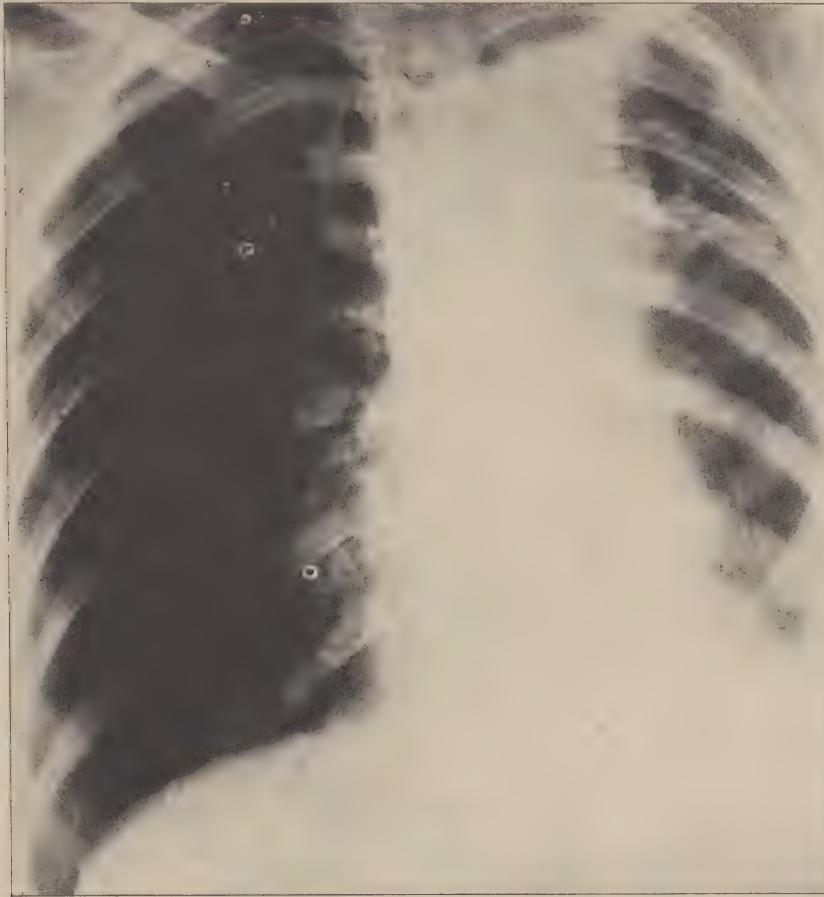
Preoperative. The process present in the left upper lobe essentially unchanged compared with postpneumothorax roentgenograms, and with that from 1936.
